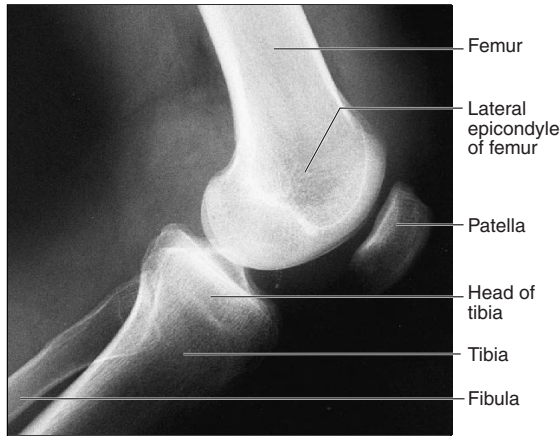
A radiograph of the right knee.
